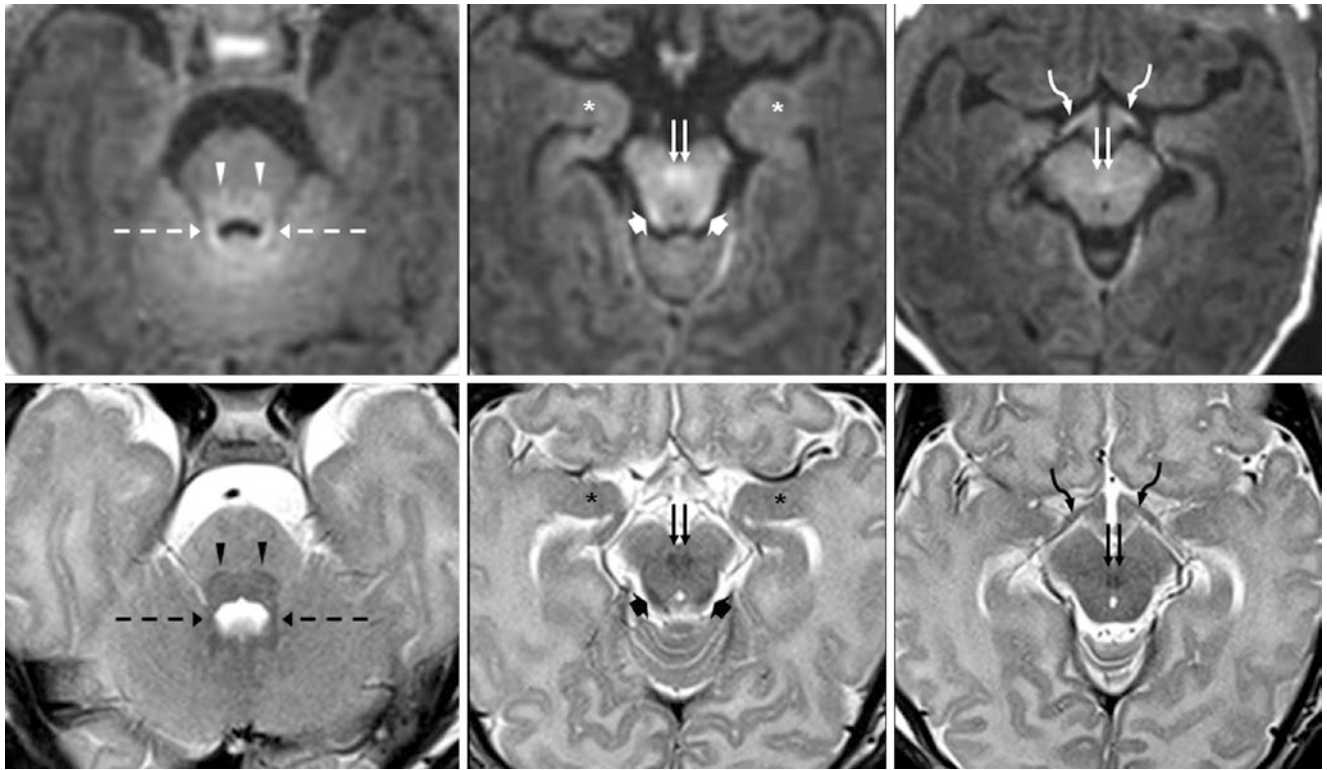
A 4-day-old term neonate had a normal 3T MRI with GE T1WIs (*top row*) and SE T2WIs (*bottom row*). Note the brachia of the inferior colliculi (*BIC*) (*wide arrows*), the decussation of the SCP (*DSCP*) (*double arrows*), the ML (*arrowheads*), and the SCP (*dashed*
